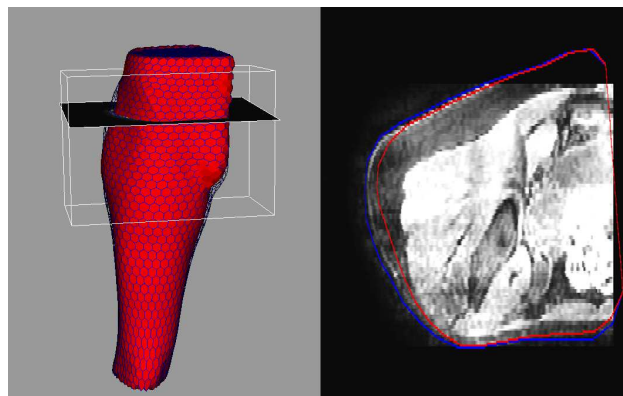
Skin tracking from sequential MRI (small amplitude posture): initialisation (red) and fitted surface (blue)
